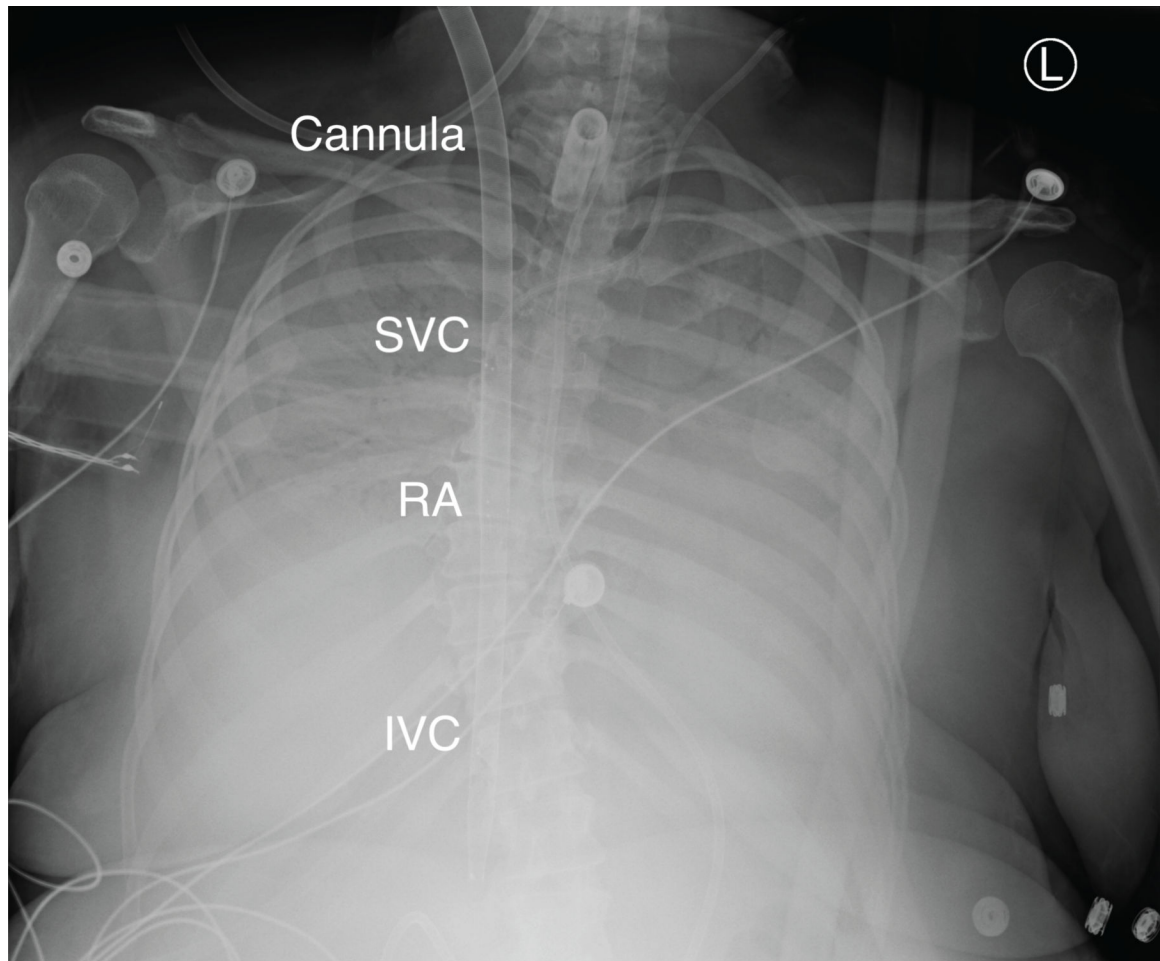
Radiographic appearance of dual lumen veno-venous ECMO cannula.
